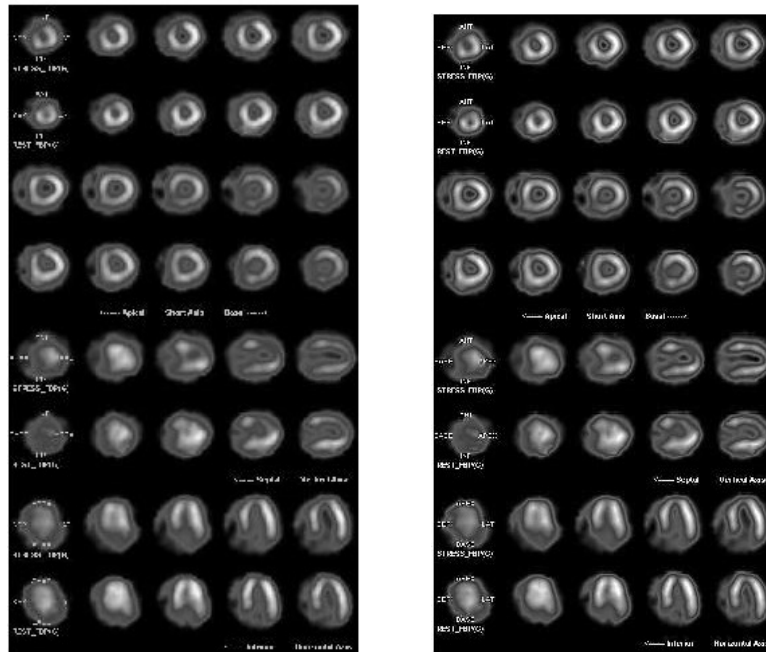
A normal perfusion SPECT image and SPECT image enhanced using the proposed method
